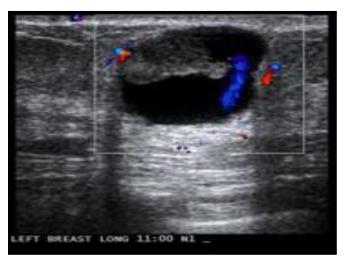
Ultrasound shows intracystic papillary breast carcinoma. (34).
